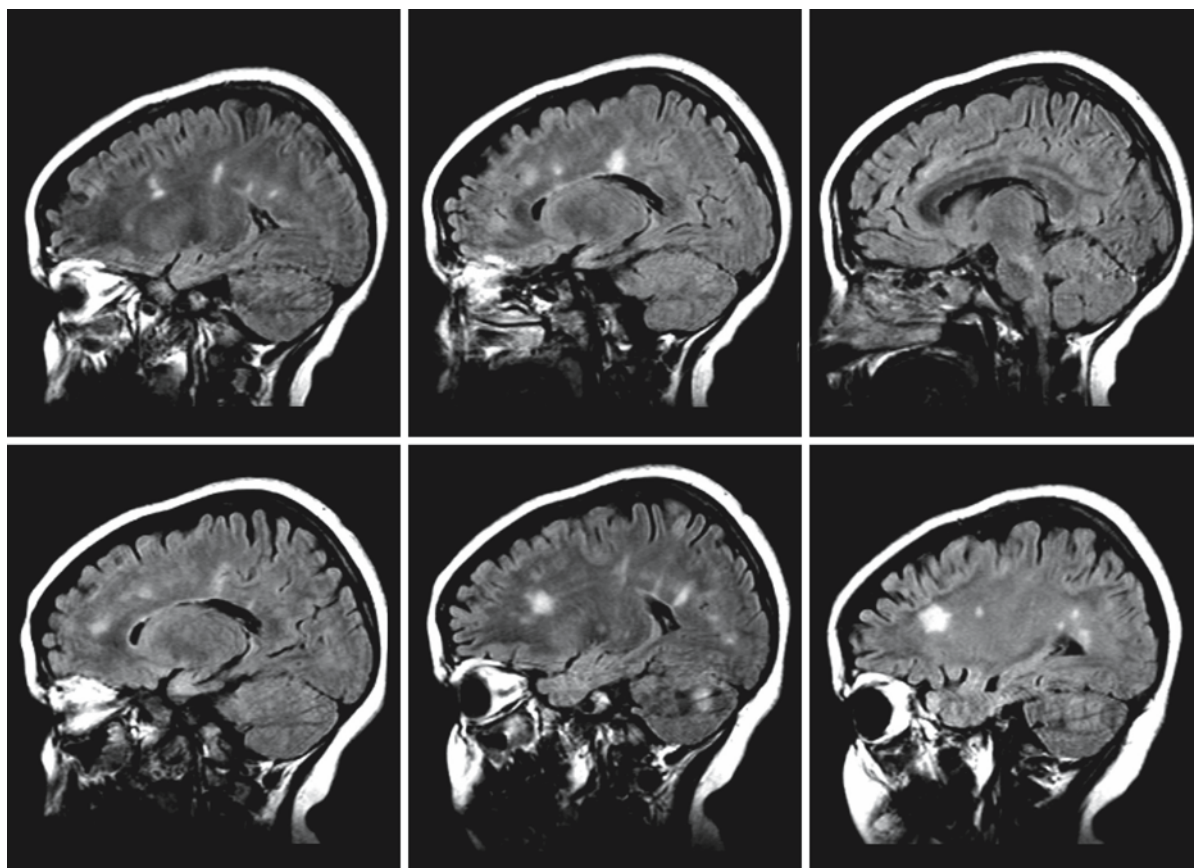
Sagittal FLAIR images in a boy of 13 years shows the classic pattern of adult MS
